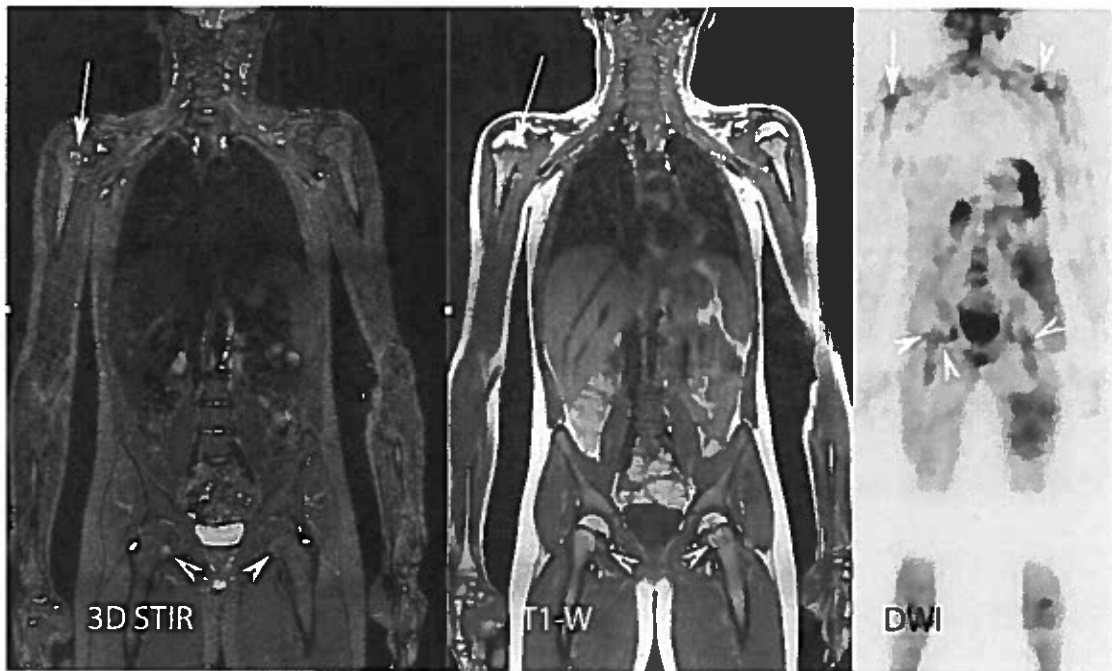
Lymphoma WB-MRI.
